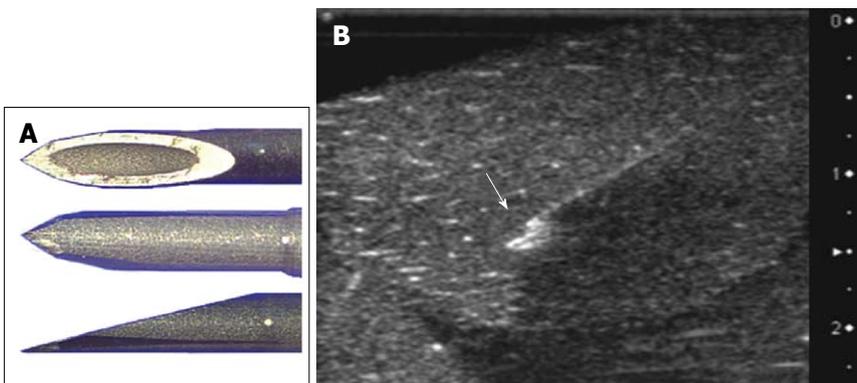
Vascular needle with re-cutting of the dorsal aspect of the tip. A: Needle tip; B: Corresponding ultrasound image. The arrow indicates the needle tip.
